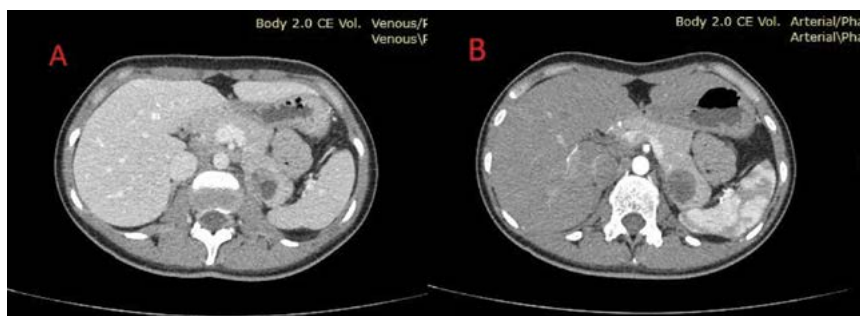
Contrast enhanced CT scan with shows a solid-cystic tumour involving the pancreatic tail (A and B)
